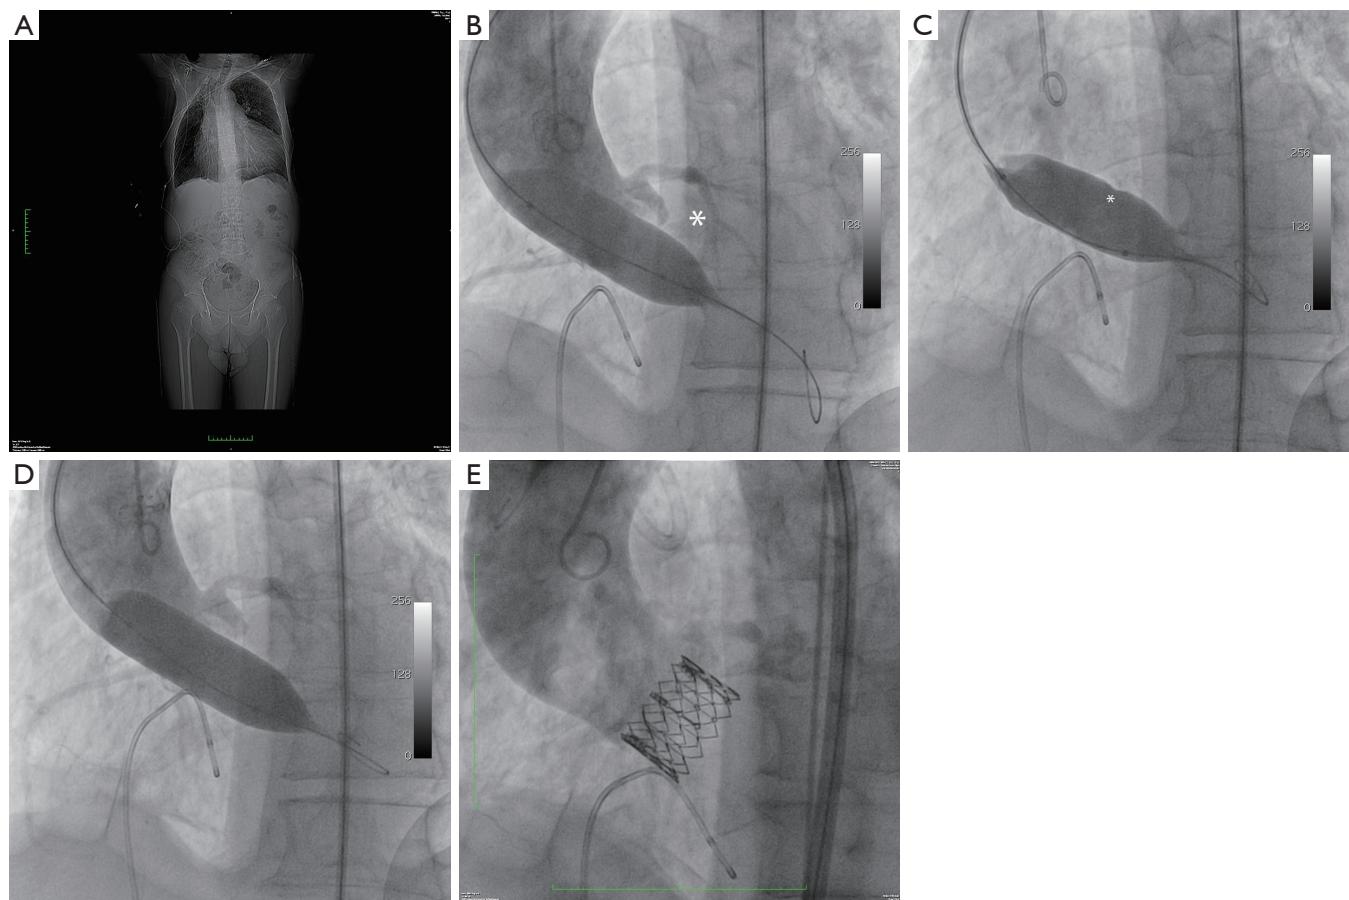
(A) A 72 year-old patient with right fibrothorax was evaluated at our TAVI-dedicated outpatients clinic. He was on domiciliary oxygen therapy and had severe left ventricular dysfunction. Echocardiography showed the presence of a bicuspid aortic valve. The annulus size was 23.5 mm at echo and 22 mm × 24 mm at chest CT. However the measurement was doubtful due to the presence of massive calcifications and to the anomalous anatomy. The patient was addressed to percutaneous TAVI with a 26 mm Edwards Sapien valve; (B) Calibrated balloon valvuloplasty with a 23 mm balloon was performed. At full inflation, the aortography demonstrated a significant para-balloon leakage (*). Moreover, no waist was generated on the balloon, and the intra-balloon pressure did not rise. The procedure was repeated with a 25 mm balloon. At this time, a waist was evident on the balloon (*, C), and the aortography at full balloon inflation showed no leak (D). The patient was addressed to TAVI with a larger device. Since we felt that opening the left pleural cavity for a transapical implant could have added a significant burden on the respiratory function of this particular patient, he was discharged home and closely monitored while waiting for the commercialization of the 29 mm percutaneous device, which was successfully implanted in May, 2012 (E)
